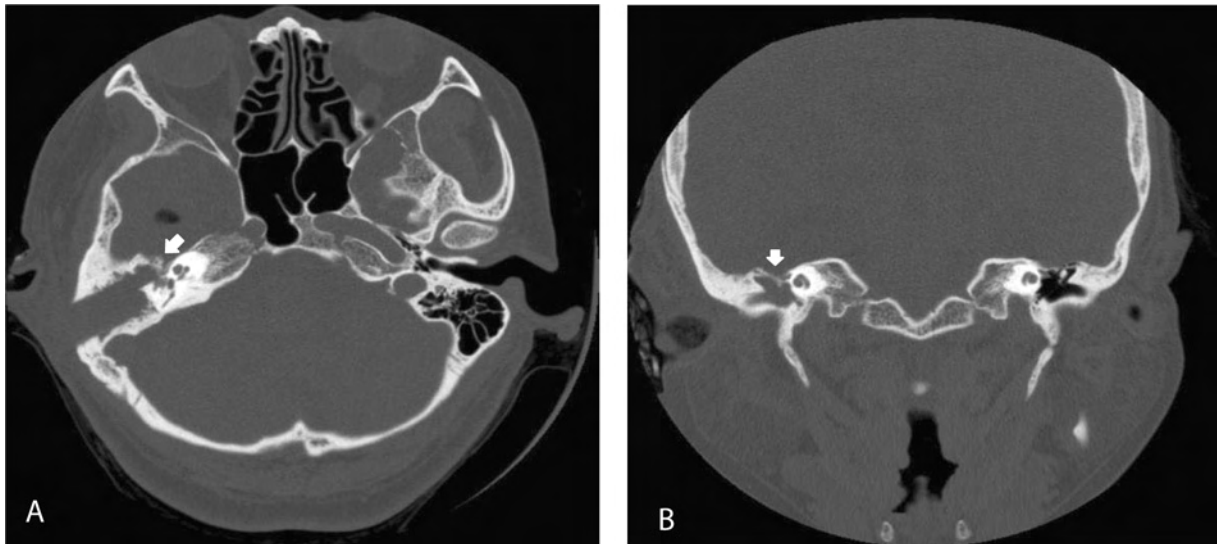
HRCT of the temporal bone one week post-operative. Axial (A) and coronal (B) images show bone chip graft covering the defect of the right middle cranial fossa (white arrow). Pneumocephalus was noted in the right temporal lobe (black arrow).
